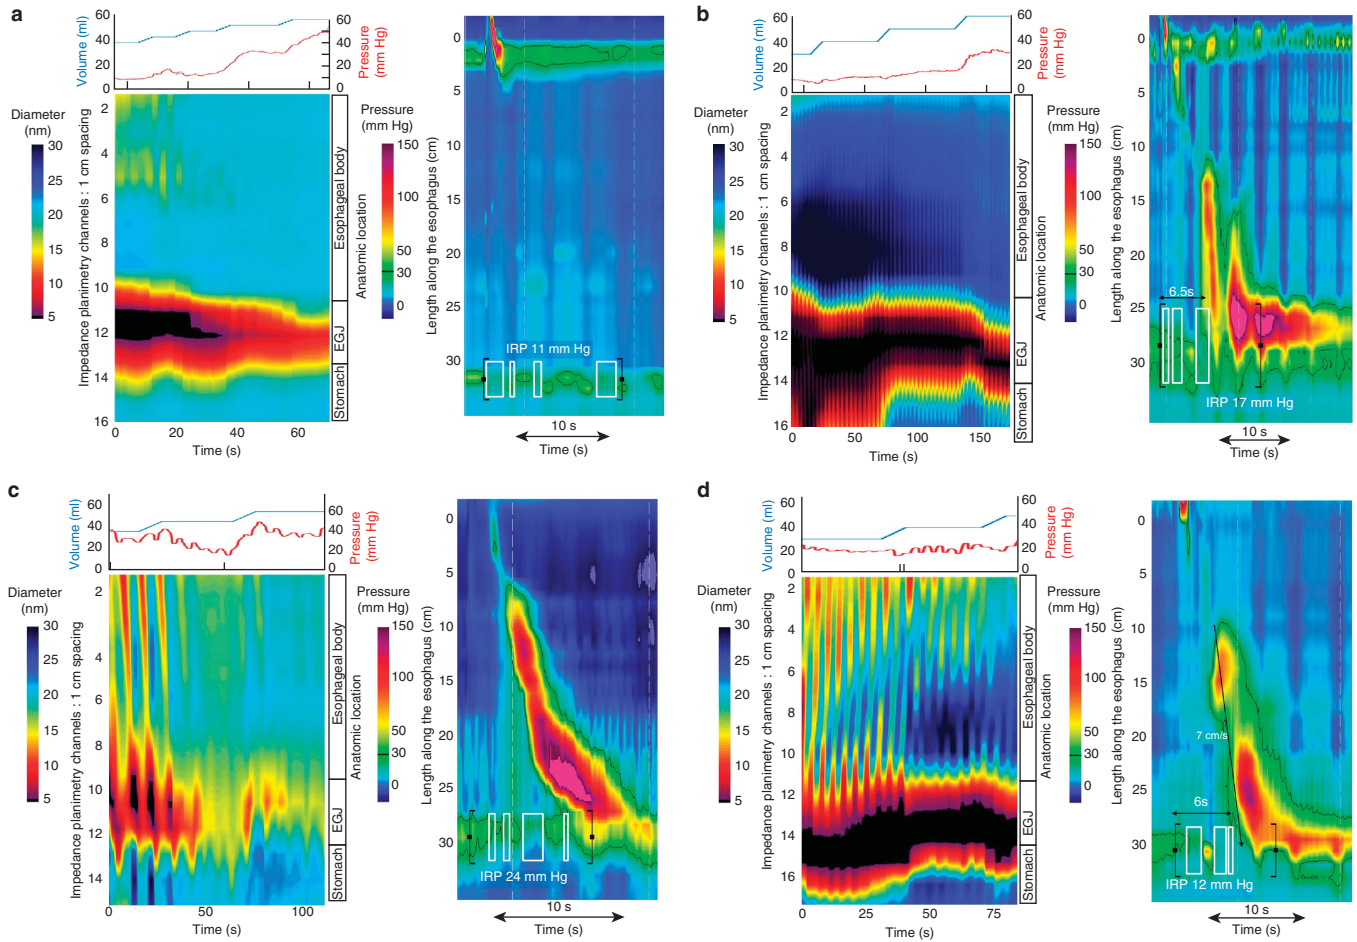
Case examples of functional lumen imaging probe (FLIP) topography. Left panels represent portions of the FLIP study: distension volume (top, blue line), and intra-balloon pressure (top, red line), and FLIP topography (bottom). A swallow from the corresponding high-resolution manometry (HRM) is included in the right panels. (a) A patient with type I achalasia, but borderline integrated relaxation pressure (IRP; median 12 mmHg). FLIP topography demonstrated an abnormal EGJ-DI of 1.6 mm²/mmHg and absent contractility. (b) A patient with EGJ outflow obstruction (EGJOO), and suspected evolving achalasia, on HRM. FLIP topography demonstrated abnormal EGJ-DI and absent contractility, supporting the diagnosis of achalasia. The patient was treated with a botulinum toxin injection to the lower esophageal sphincter that resulted in improvement in dysphagia. (c) A patient with EGJOO on HRM. FLIP topography was essentially normal with a normal EGJ-DI (4.9 mm²/mmHg) and RACs. An esophagram showed normal clearance of barium. Dysphagia had resolved without intervention at 6-month follow-up. (d) A patient with normal motility on HRM (median IRP 13 mmHg), but with an abnormal EGJ-DI (0.46 mm²/mmHg) and RRCs on FLIP topography. Esophagram demonstrated persistent esophageal barium column height of 4.4-cm after 5 min and impaction of a 12.5-mm barium tablet at the EGJ. The patient underwent endoscopic ultrasound with diffusely thickened distal esophageal muscle layers supporting diagnosis of a primary esophageal motor disorder. A per-oral endoscopic myotomy was recommended.
